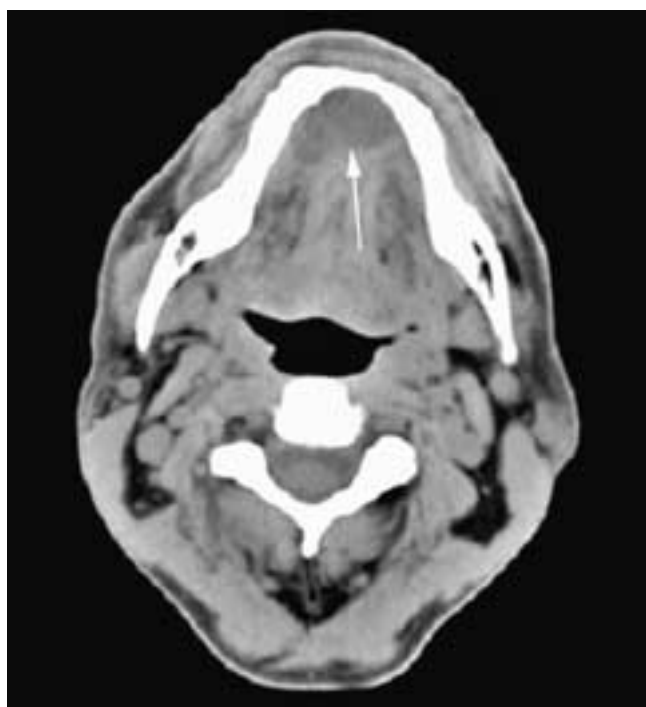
Axial CT scan shows a localized low-attenuation mass (*arrow*) in the midline extending from the anterior right sublingual gland across to the left side. This ranula remained above the mylohyoid muscle. This long-standing ranula has slightly remodeled the lingual cortex of the mandibular symphysis.
